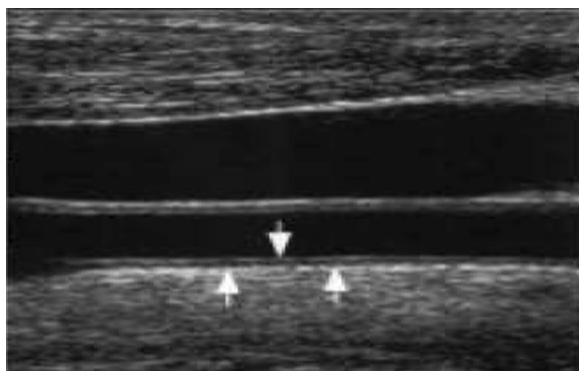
Gray-scale carotid doppler ultrasound shows the normal vascular diameter with normal intimal media complex is less than 0.8 mm
